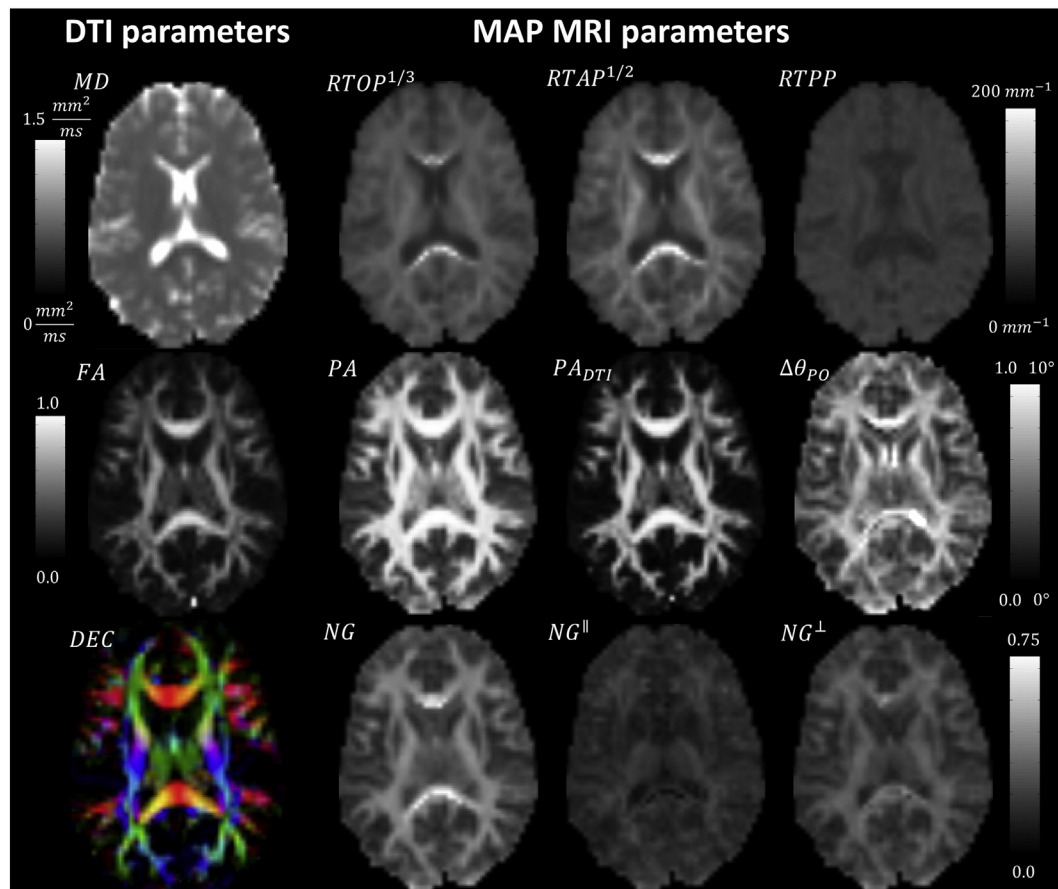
Neuroanatomical variation of MAP MRI and DTI microstructural parameters in a representative subject. DTI-derived parameters: MD, FA, and directionally encoded color (DEC) map (left). MAP MRI-derived zero-displacement probabilities, propagator anisotropy and non-Gaussianity indices (right).
